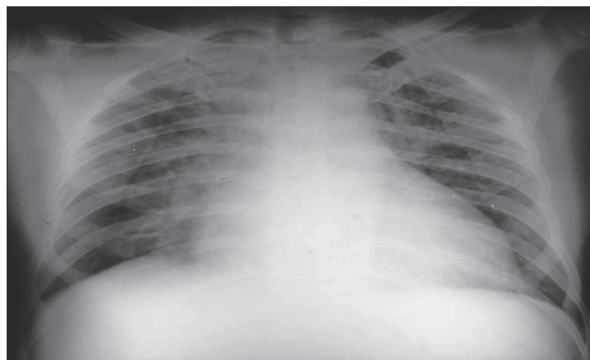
Chest radiograph showing congestive heart failure in a patient with malignant hypertension.
